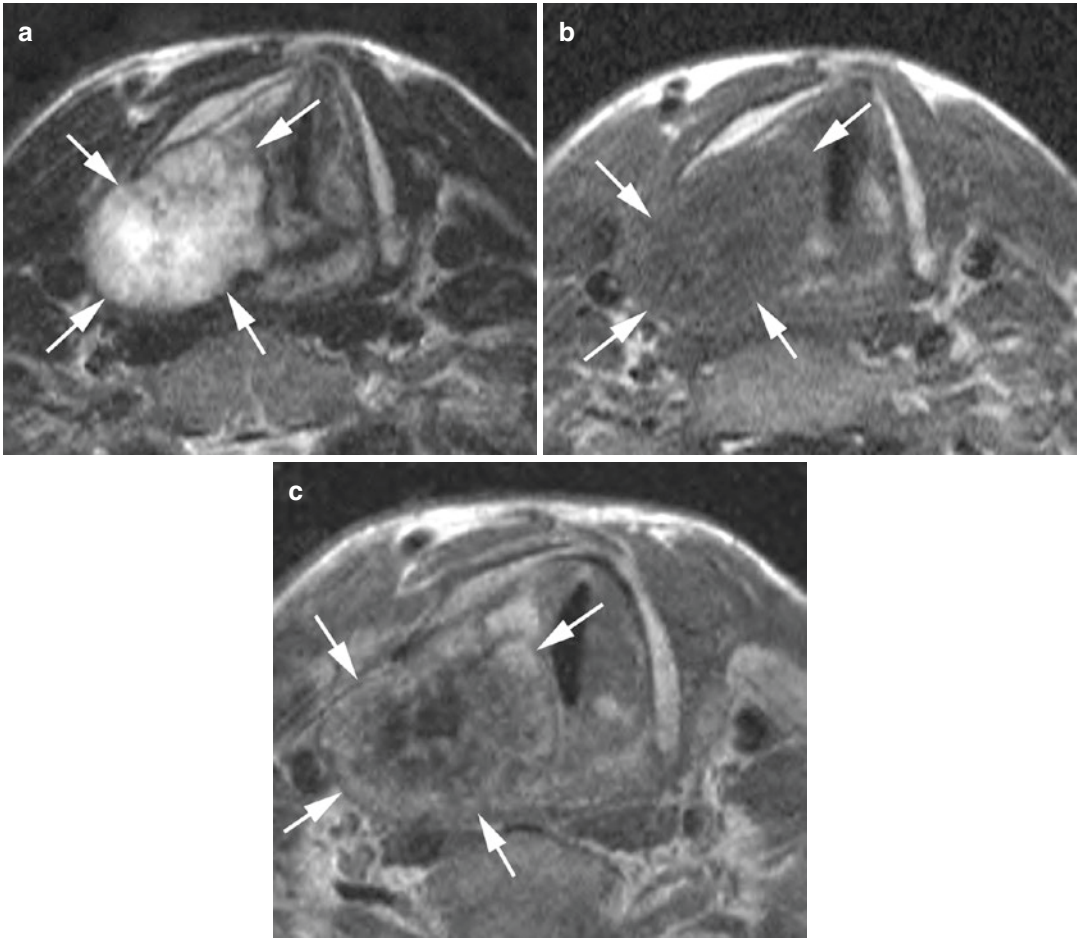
MR appearance of a large low-grade chondrosarcoma originating from the cricoid cartilage. (a) Axial T2-weighted spin echo image shows a lobulated mass (arrows) with high signal intensity. (b) Axial T1-weighted
